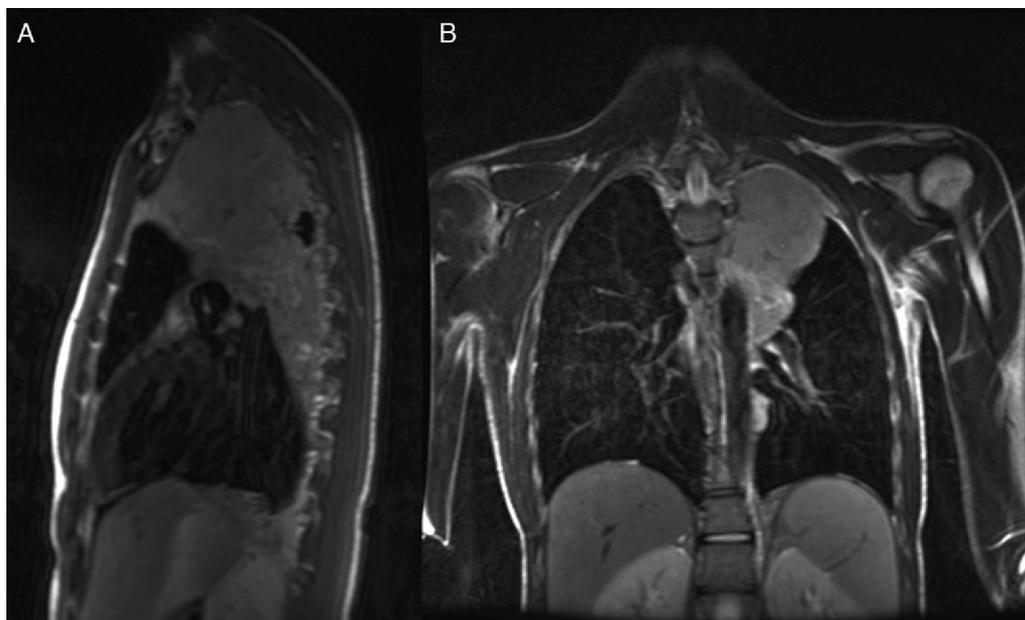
Non-contrast chest MRI (T2 sequence): lobulated mass in the upper region of the left hemithorax, of extrapulmonary appearance, derived from the pleura. (A) Sagittal section. (B) Coronal section.
